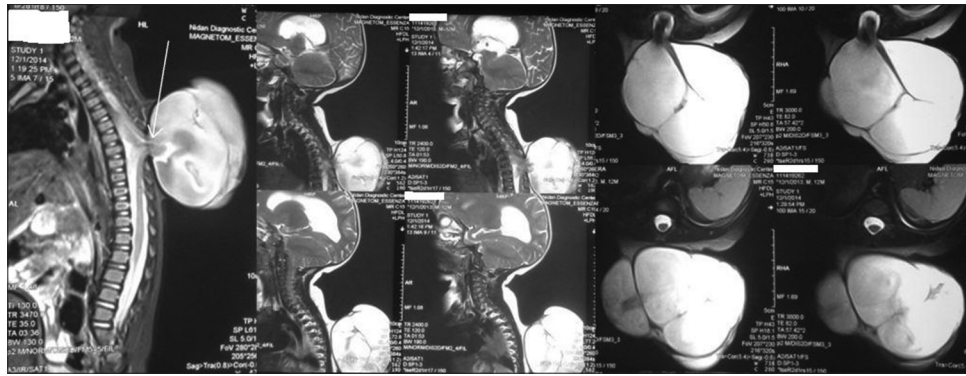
Magnetic resonance imaging thoracic region shows a small neural placode at the base of swelling (arrow) with a stalk connecting the placode with dural covering. Multiseptated nature of the swelling can be seen along with hydrocephalus
